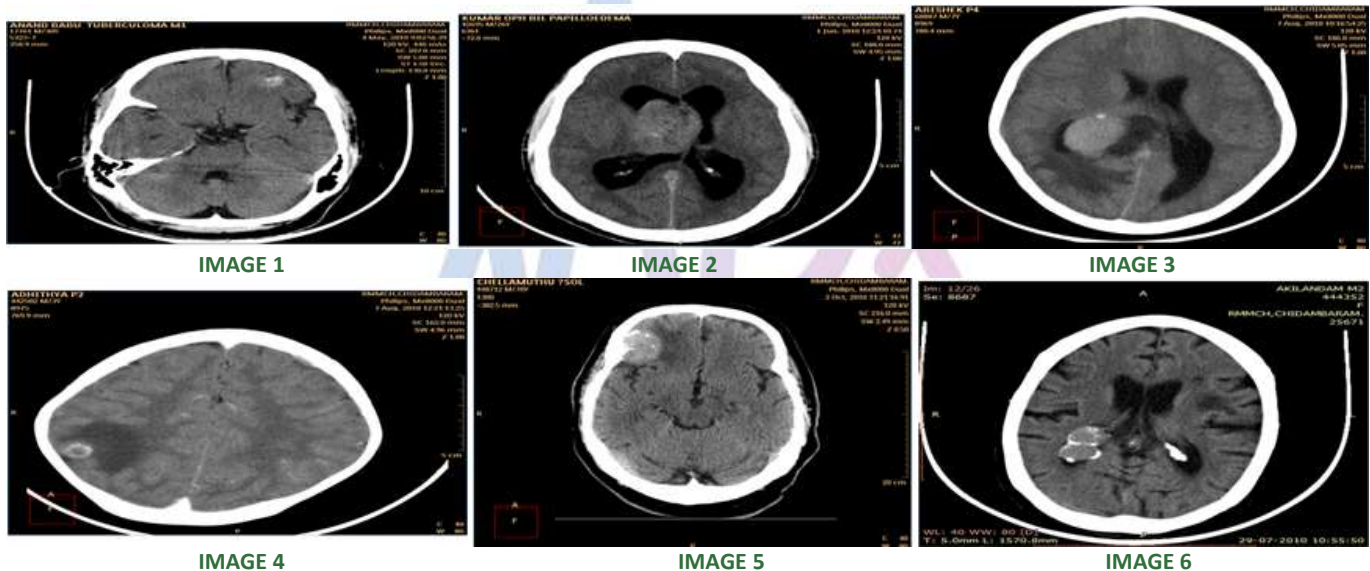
CT AXIAL SECTION OF TUBERCULOMA SHOWING HYPERDENSE LESION IN THE LEFT FRONTAL REGION; IMAGE 2: CT AXIAL SECTION OF MENINGIOMA SHOWING SOFT TISSUE DENSE MASS IN THE RIGHT PARASAGITTAL REGION WITH A HYPERDENSE FOCI; IMAGE 3: CT AXIAL SECTION OF PILOCYTIC ASTROCYTOMA SHOWING SOFT TISSUE DENSE MASS IN THE RIGHT PARIETAL REGION WITH HYPERDENSE FOCI AND PERILESIONAL EDEMA; IMAGE 4: CECT AXIAL SECTION OF TUBERCULOMA SHOWS A RING ENHANCING TARGET LESION WITH PERILESIONAL EDEMA; IMAGE 5: CT AXIAL SECTION OF MENINGIOMA SHOWS EXTRA AXIAL MASS WITH HYPERDENSE FOCI WITH MASS EFFECT, PERILESIONAL EDEMA; IMAGE 6: CT AXIAL SECTION OF CHOROID PLEXUS PAVILLOMA SHOWING SOFT TISSUE DENSE MASS WITH CALCIFICATION IN THE RIGHT OCCIPITAL HORN OF LATERAL VENTRICLE
